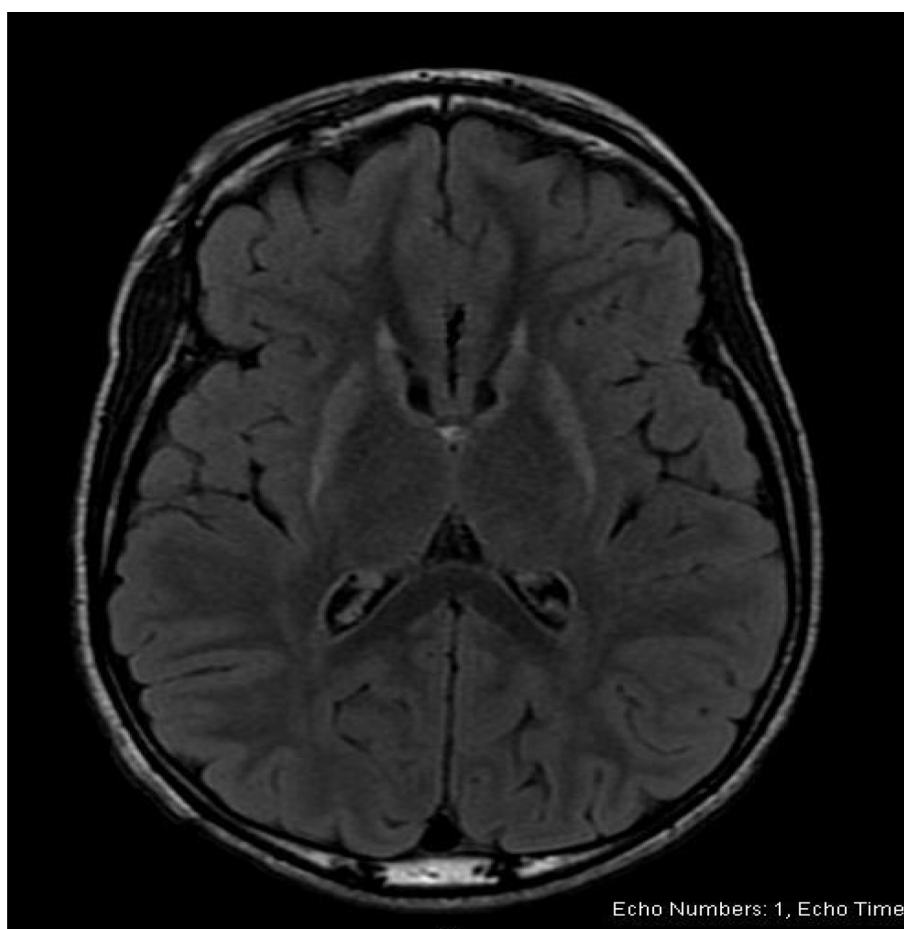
Axial view T2/FLAIR MRI sequence demonstrating volume loss of the caudate nuclei bilaterally that resulted in mild expansion of the frontal horns of the lateral ventricles bilaterally.
